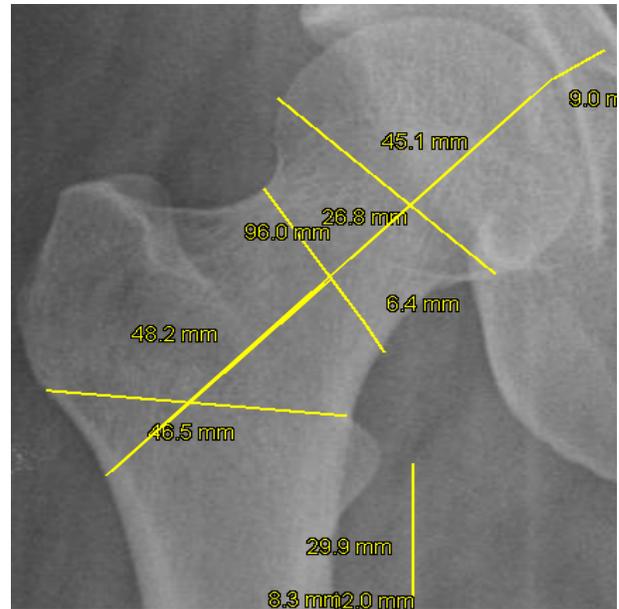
Hip geometrical measurements on a digital radiograph of Normal Post Menopausal Indian woman aged: 54, the measured Total hip BMD by the DXA in the same individual was: 1.021 g/ Cm 2
